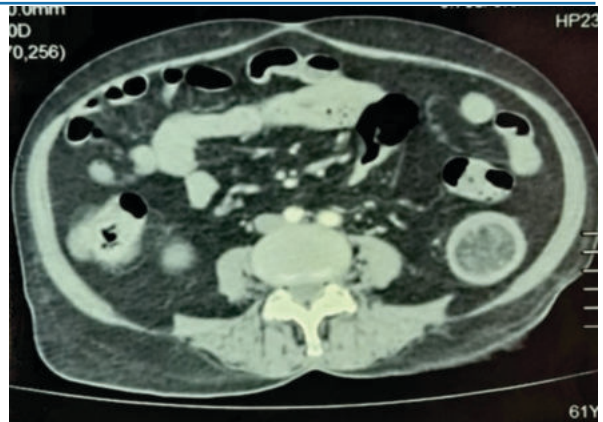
[B] CT showing intraluminal mass at splenic flexure
